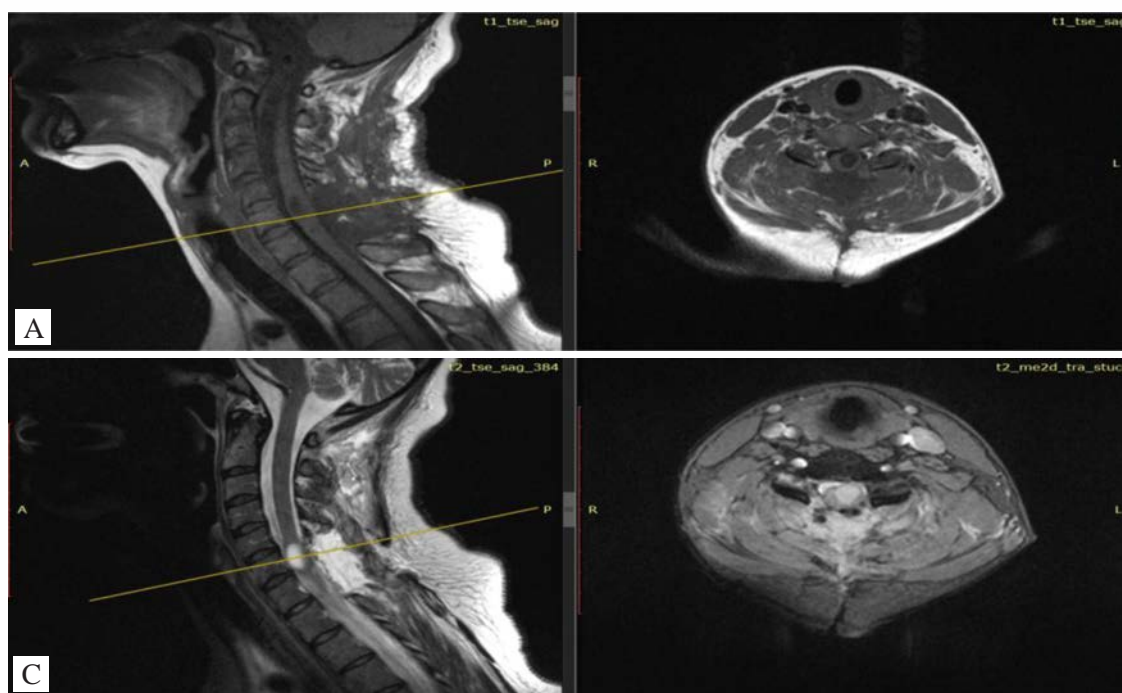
MRI of the cervical spine after surgery.
